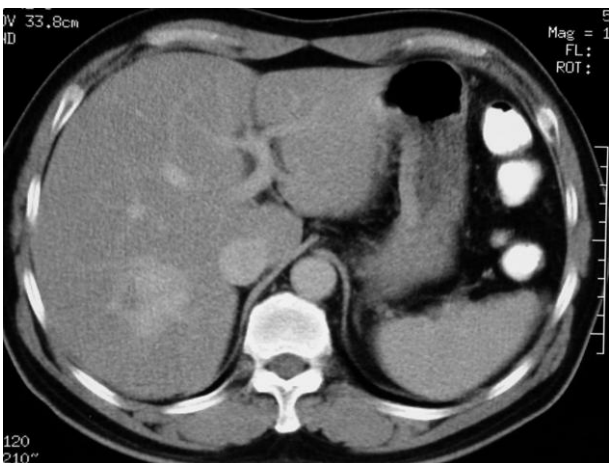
Delayed phase CT image shows pooling of contrast medium into the central part of the hepatic mass. Hemangioma is compatible.
